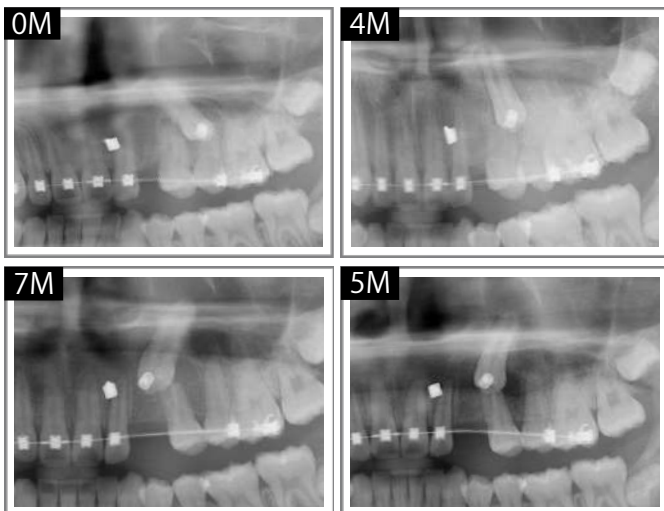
Panoramic radiographs in clockwise order document the movement of the UL3:
